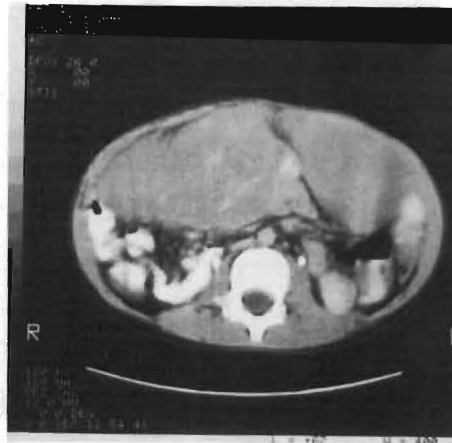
CT scan investigation of the epigastric mass depicted in Fig. 25, further defining a large, solid, non-invading mass anteriorly in the epigastrium. CT studies proved to be an excellent method of following the lesion.
